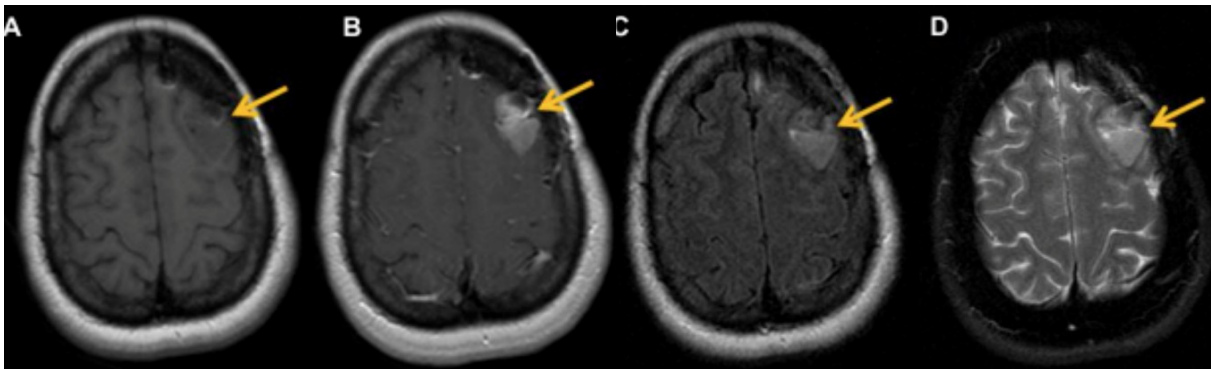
MRT-morphology of left frontal GBM: (adapted from [5]) A: Axial view shows a hypointense lesion B: T1 post contrast image with irregular enhancement. C: T2 FLAIR images show increase in FLAIR signal. D: T2 FSE images also demonstrate increase in signal
